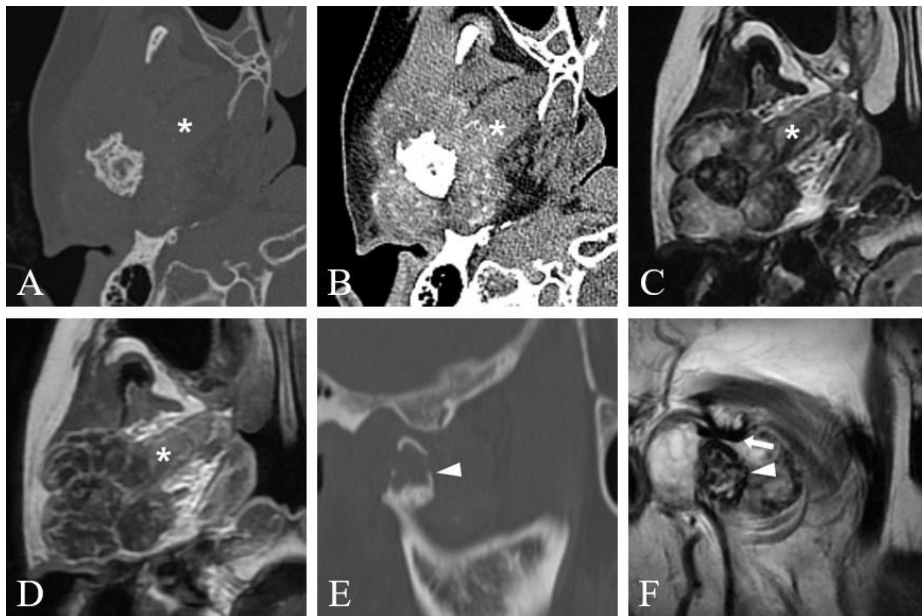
Representative images of chondrosarcoma of the right TMJ in a 54-year-old woman. (A–D) Axial MDCT, non-fat-suppressed T2-weighted MR, and contrast-enhanced T1-weighted MR images demonstrate a large mass infiltrating into the tendon of the lateral pterygoid muscle (asterisk) in the pterygoid fovea and showing septa-like internal enhancement. Stippled calcification and severely destroyed mandibular condyle with periosteal reaction are also revealed. (E and F) Sagittal MDCT and T2-weighted MR images present the mass epicenter of the mandibular condyle (arrow head). Note the disc (arrow) located between the destroyed mandibular condyle and the intact articular eminence.
